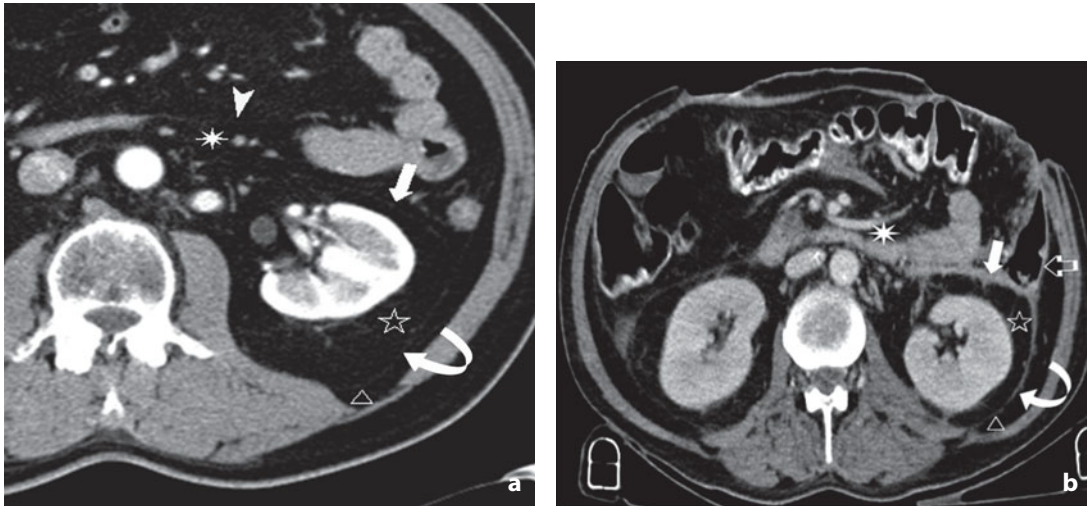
Computed tomography. Axial scan. Perirenal and pararenal spaces. a The anterior pararenal space (*asterisk*) is bounded by the posterior parietal peritoneum (*arrowhead*) and the anterior perirenal fascia (*arrow*). The perirenal space (*star*) is bounded by the anterior perirenal fascia and the posterior perirenal fascia (*curved arrow*). The posterior pararenal space (*triangle*) is bounded by the posterior perirenal fascia and the transverse fascia, which covers the psoas and quadratus lumborum muscles, and is only visible in its lateral portion. b The spaces are better defined when the fasciae are thickened. The unfilled arrow indicates the lateroconal fascia
